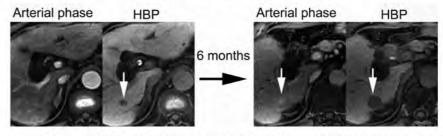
A nodule showing hypovascularity in arterial phase and hypointensity in hepatobiliary phase (HBP), which became hypervascular hepatocellular carcinoma in 6 months. The nodule was supposed to be hypovascular (early stage) hepatocellular carcinoma even at the initial MRI.
